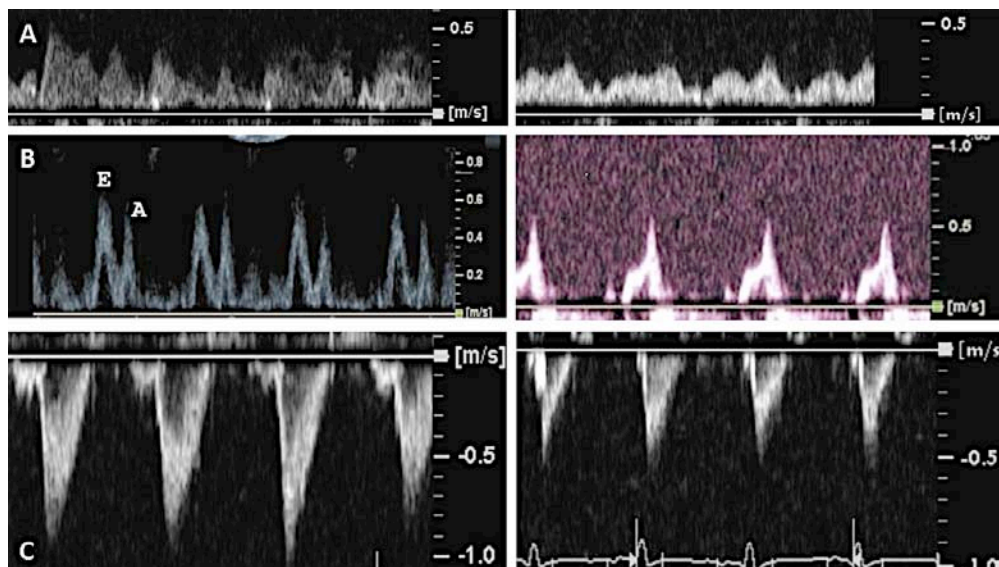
Two-dimensional echocardiography images demonstrating reduction in pulmonary venous peak velocity (Panel A), ratio of passive (E wave) to active (A wave) transmitral flow (Panel B), and left ventricular output (Panel C) after surgical ligation of the ductus arteriosus.
